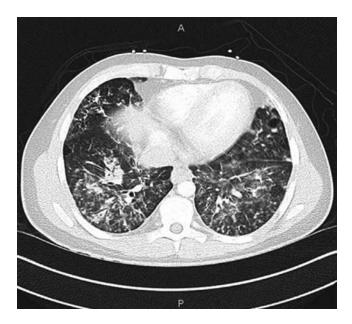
Computed tomography of the chest showing bilateral patchy and confluent ground-glass opacities and consolidative abnormalities consistent with a diagnosis of nonspecific interstitial pneumonia.
